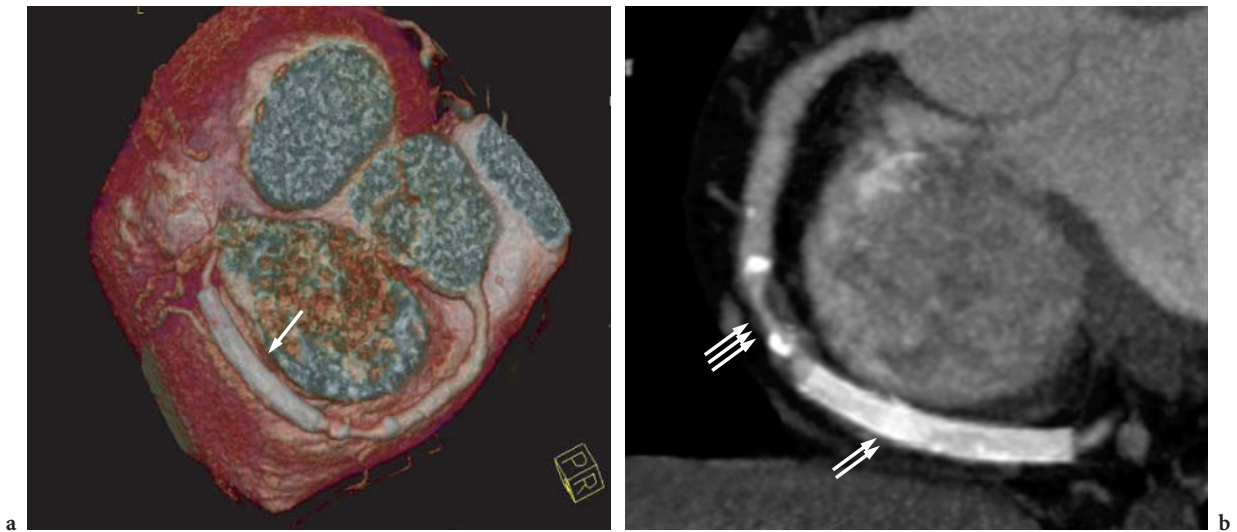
Manually defined curved MIP with 5-mm slab thickness for a coronary artery examination obtained on a 16-slice CT scanner with 16×0.75 -mm collimation. The in-stent lumen of the stent in the distal RCA can be demonstrated in VRT display (a, *arrow*) and cannot be adequately visualized with curved MIP reconstruction (b, *double arrow*). Therefore, MPR is to be preferred over MIP for the visualization of in-stent lumen. However, visualization of the stenotic lesion and the corresponding mixed plaque (b, *triple arrow*) is excellent. (Case courtesy of HSC Medical Center, Kuala Lumpur, Malaysia)
